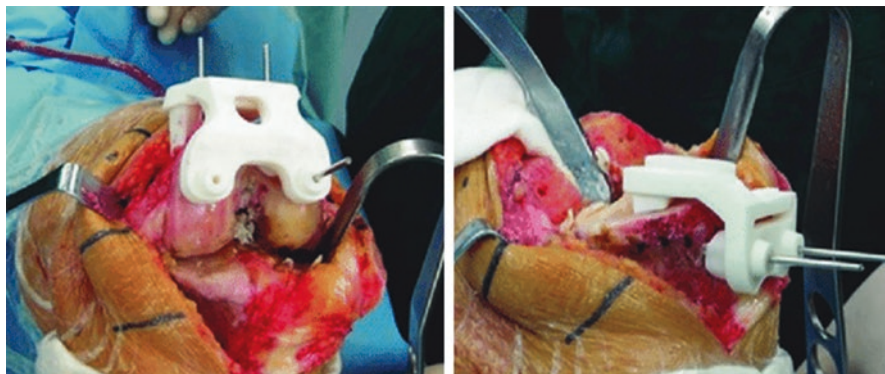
Example of 3D printed patient-specific distal femur and proximal tibia cutting guides. (Image taken from: Patient-Specific Instruments Based on Knee Joint Computed Tomography and Full-Length Lower Extremity Radiography in Total Knee Replacement - Scientific Figure on ResearchGate. Available from: https://www.researchgate.net/figure/Representative-images-of-primary-total-knee-replacement-guided-by-patient-specific_fig1_323558012 [accessed 22 Sep 2020])
